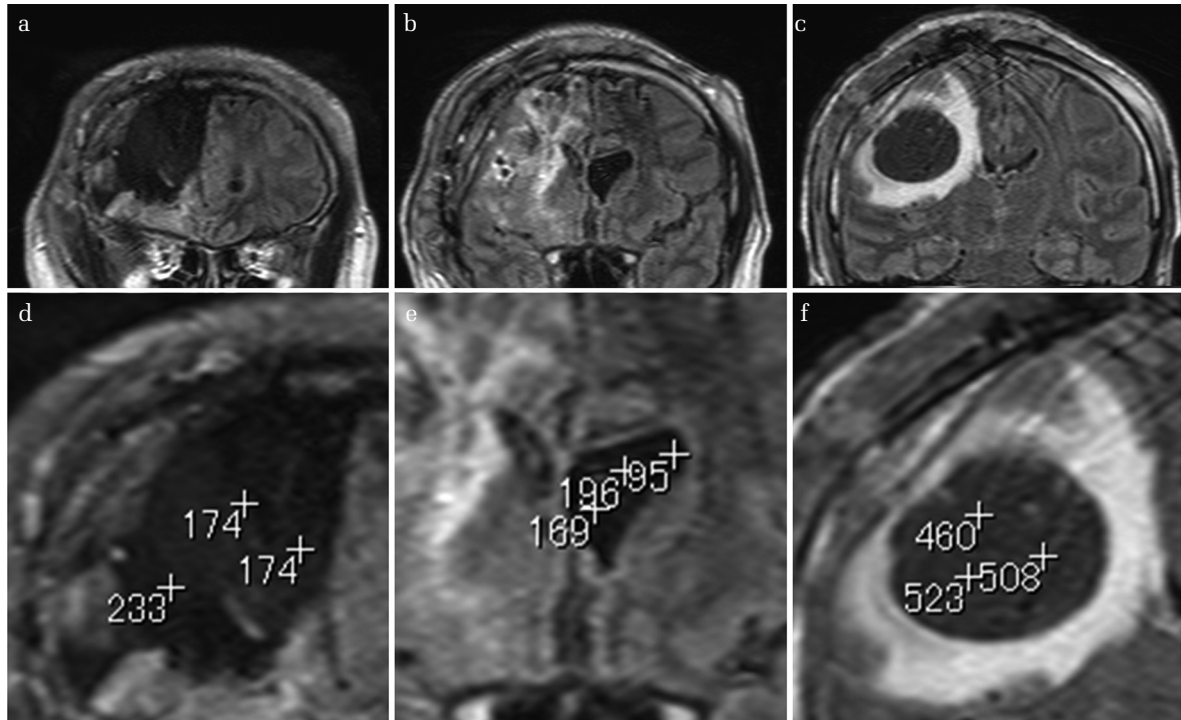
Intensity difference of tumor resected cavity, lateral ventricle, and cyst on fluid-attenuated inversion recovery (FLAIR) images. FLAIR images taken under the same imaging parameters show the different intensities in the tumor resected cavity (a), a contralateral lateral ventricle as a control value of CSF (b), and the cyst (c). Each column (a–c) shows same coronal FLAIR image (upper, original images; lower, magnified images with intensity values of randomly selected three points).
